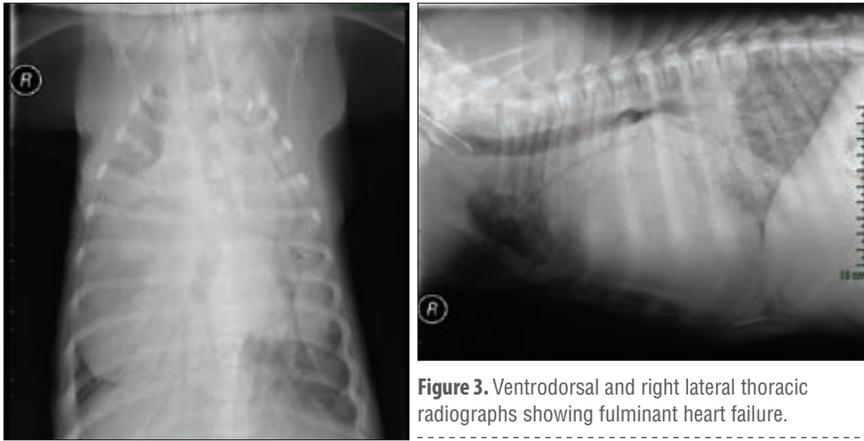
Ventrodorsal and right lateral thoracic radiographs showing fulminant heart failure.
